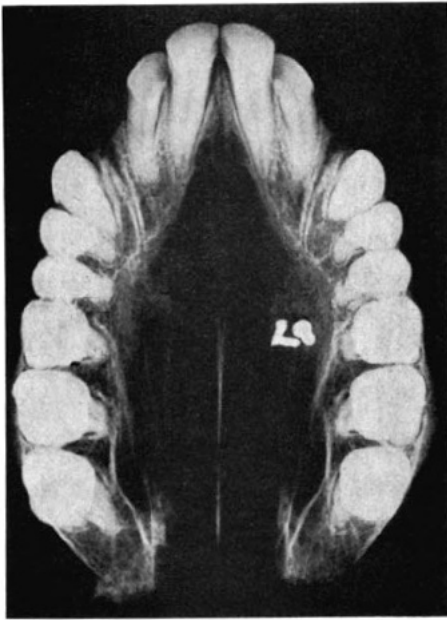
Occlusal radiograph showing extensive midline radiolucent area.
